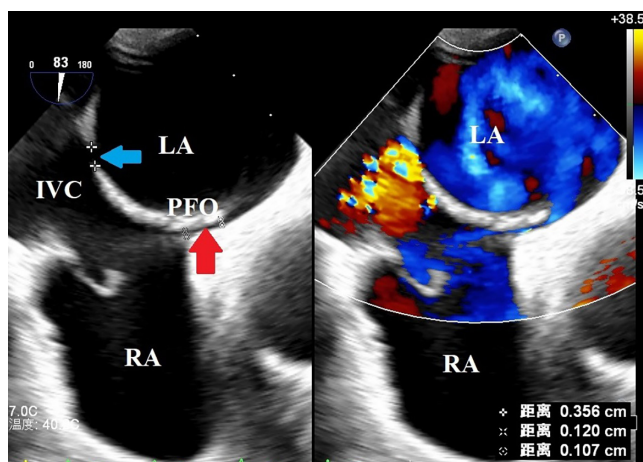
Transesophageal echocardiography images. The blue arrow indicates the echo interruption in the wall of the IVC, and the red arrow indicates the PFO. RA, right atrium; LA, left atrium; IVC, inferior vena cava; PFO, patent foramen ovale.
